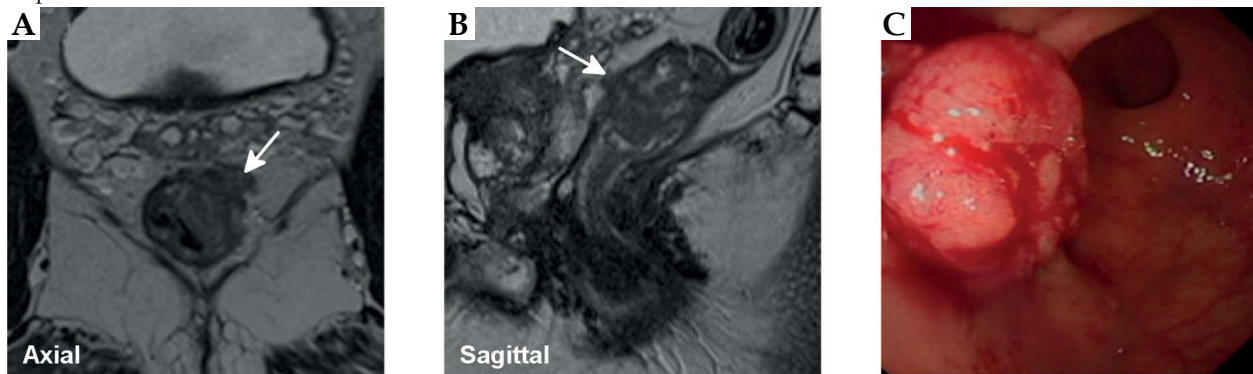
The magnetic resonance image and endoscopy at presentation demonstrated a polypoid tumor within the low rectum. This infiltrated the muscularis propria, but there was no mesorectal breach. It was staged T2 N0 (arrows, A-C). Following local resection, chemoradiotherapy and a Papillon boost, a “black spider” appearance is seen with fibrosis at the treated tumor site (arrow, D). The coronal image shows some residual intermediate signal at this time (arrow, E). Endoscopy revealed no evidence of recurrence (F). At 1-year follow-up, on magnetic resonance imaging, the fibrosis continued to mature, with no residual intermediate signal tumor remaining (arrows, G, H). On endoscopy, stenosis and ulceration was seen, but no recurrence (I). However, 1.5 years post-treatment, intermediate signal tumor recurrence is seen at the periphery of the fibrotic crater with loss of black fibrosis seen at the anterior margin extending beyond the scar (arrows, J, K). On endoscopy, a recurrent malignant mass was apparent (L)
